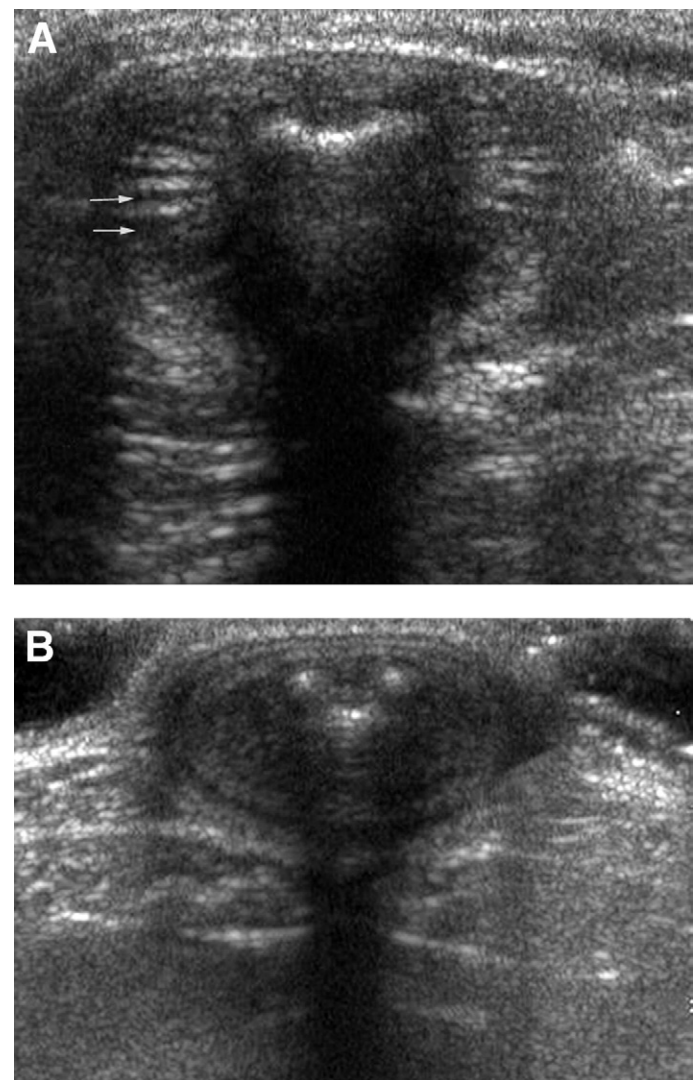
(A) Transverse ultrasound image of priapism in case 1. Note the engorged vessels in the corpus cavernosum indicated by the arrows. (B) Transverse ultrasound image of a normal nonerect canine penis. Ultrasound images courtesy of Tomas Baker.
